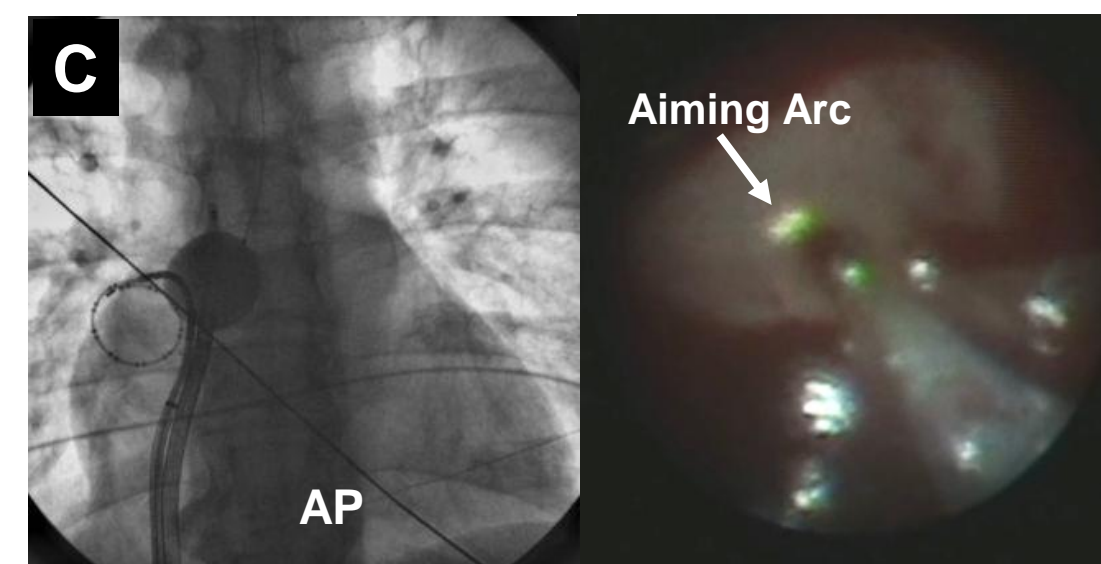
(A) The CT scan of the left atrium was registered to the 3D bipolar voltage map post-ablation. The level of isolation with each vein can be seen. (B) Endoscopic view of BAC positioned in the LCV. (C) The fluoroscopic and endoscopic views of the BAC in the left atrial roof vein are shown. (D) Endoscopic view during ablation around the RCV.
